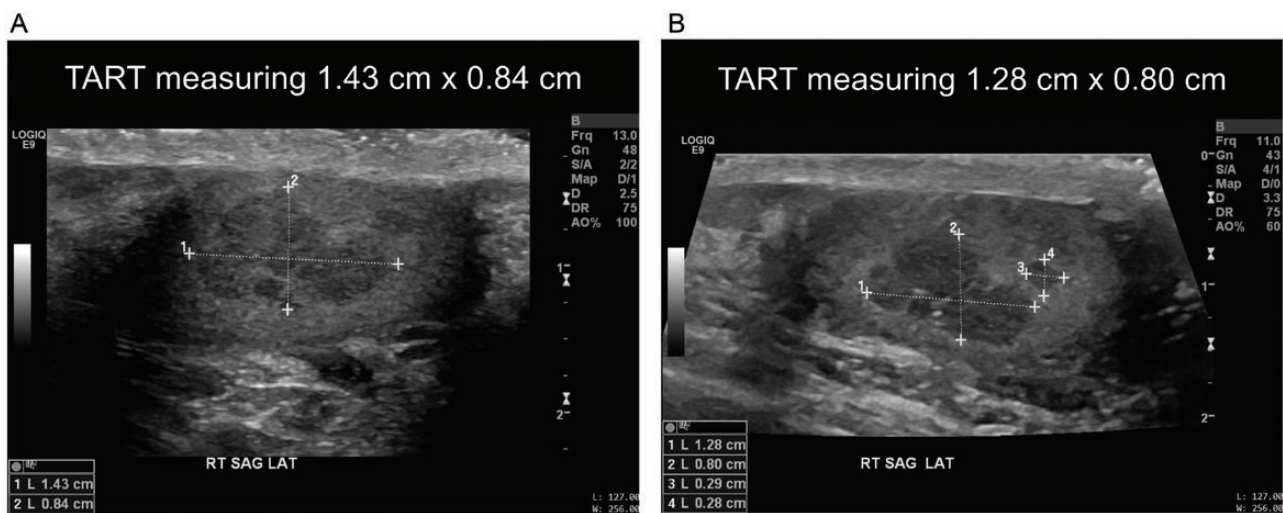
Changes in testicular adrenal rest tumor (TART) measurements in 1 participant in Study 201. Pretreatment and post 6-week tildacerfont treatment testicular ultrasounds of single TART in a participant. Treatment with tildacerfont reduced the TART approximately 23% in volume.
